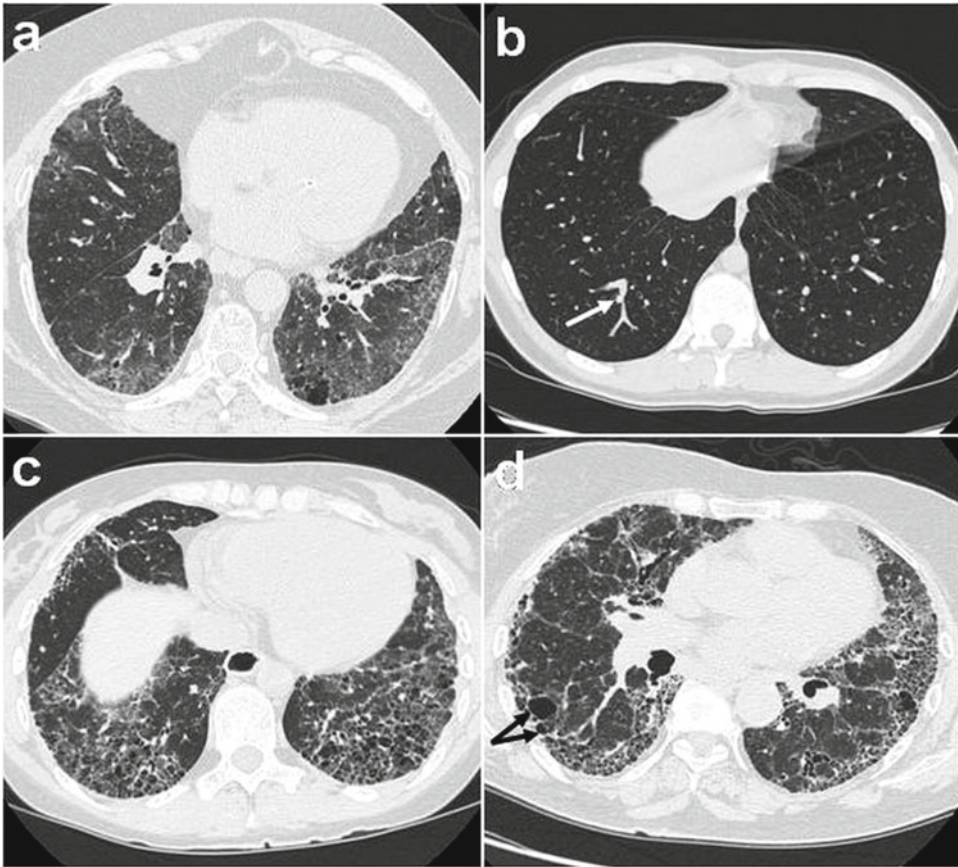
HRCT scans. (a) Both-sided ground glass opacities; (b) Septal and subpleural lines (*arrow*); (c) Areas with honeycomb in the lower lobes; (d) Subpleural cysts at the basal segment level (*arrows*)
